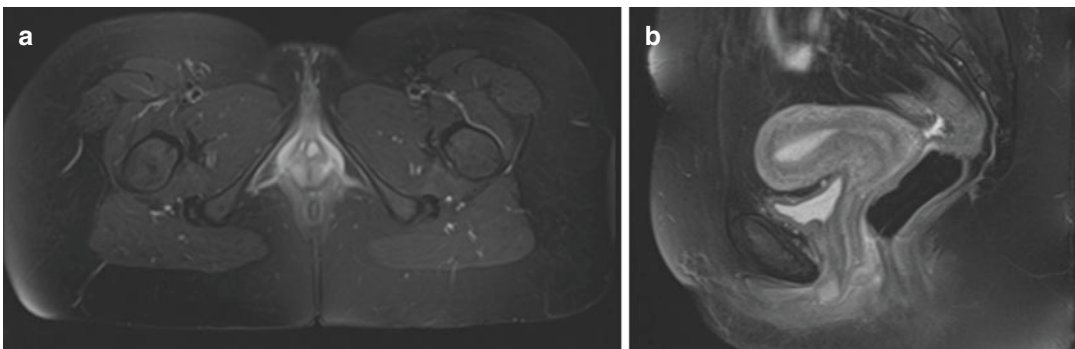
MR images of Skene's gland cyst. (a) Axial T2-weighted image with fat saturation showing 1 cm homogenous cystic structure along the left aspect of the urethra with slight deviation of the urethra to the right. (b)
